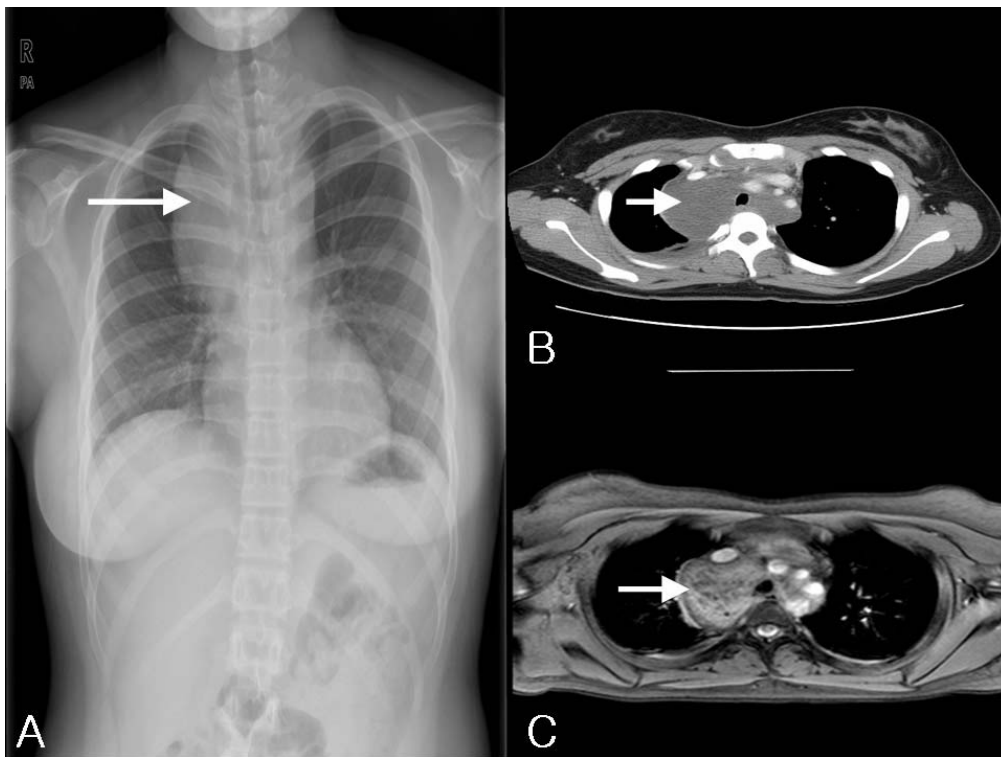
Arrow of picture showing mediastinal mass on chest x-ray(A), CT(B) and MRI(C). About 5cm sized mediastinal mass involve contralateral mediastinum and trachea and superior vena cava are compressed by this mass.
